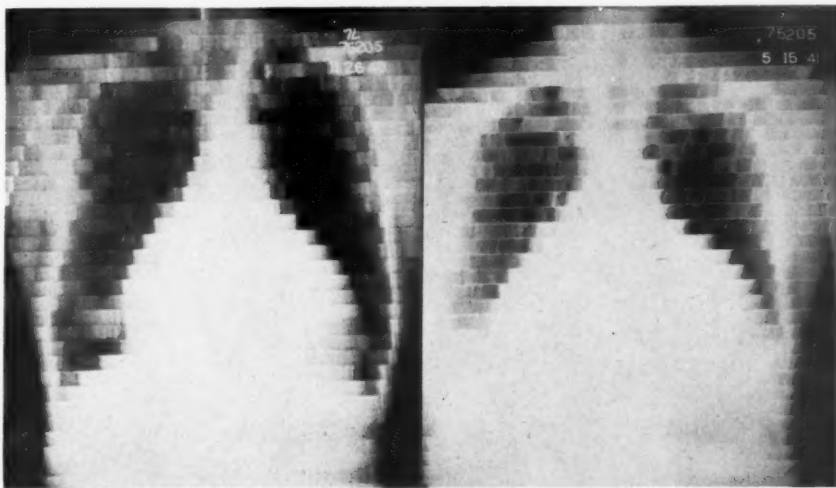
Case 1. *A*, Roentgenkymograph when patient was on irregular doses of thyroid, showing absence of pulsations over the lower third of the heart and good pulsations over the great vessels, indicating recurrence of small pericardial effusion without impairment of ventricular contraction. *B*, Recurrence of massive pericardial and small pleural effusion after complete withdrawal of thyroid therapy; the small pulsations over the great vessels indicate feeble ventricular contractions.
